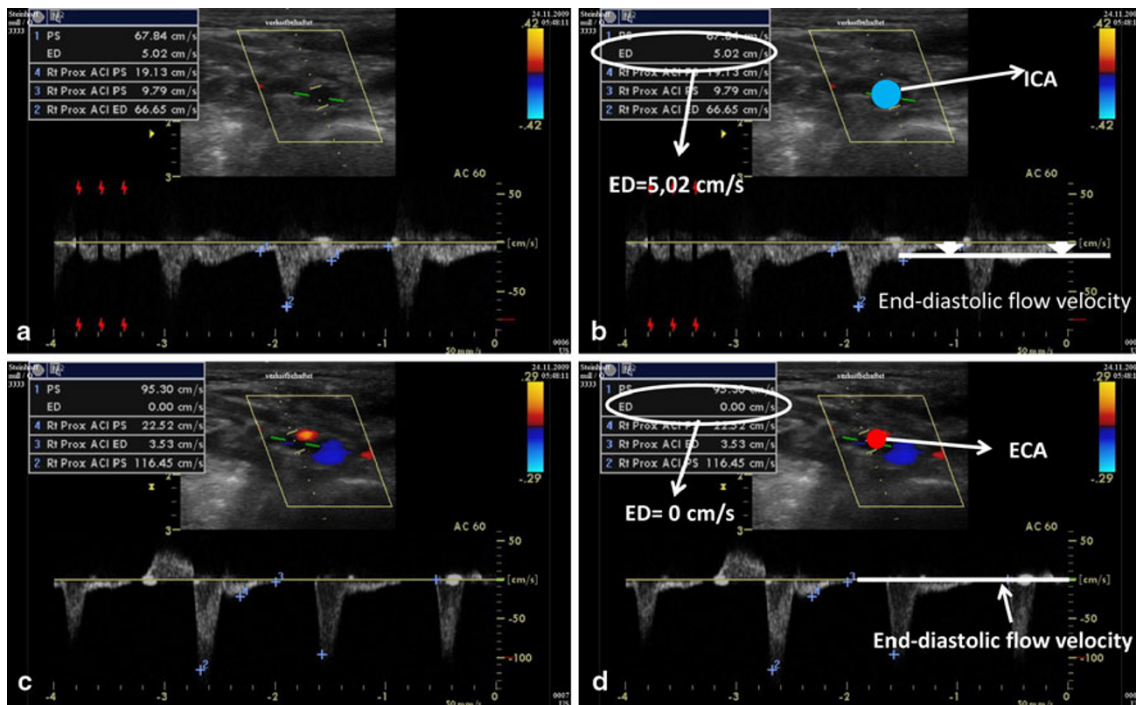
Example of duplex sonography of a patient during resuscitation and in severe cardiogenic shock (Pseudo-pulseless electrical activity, ejection fraction severely reduced (10%) after resuscitation. Extracranial internal carotid artery (ICA), external carotid artery
